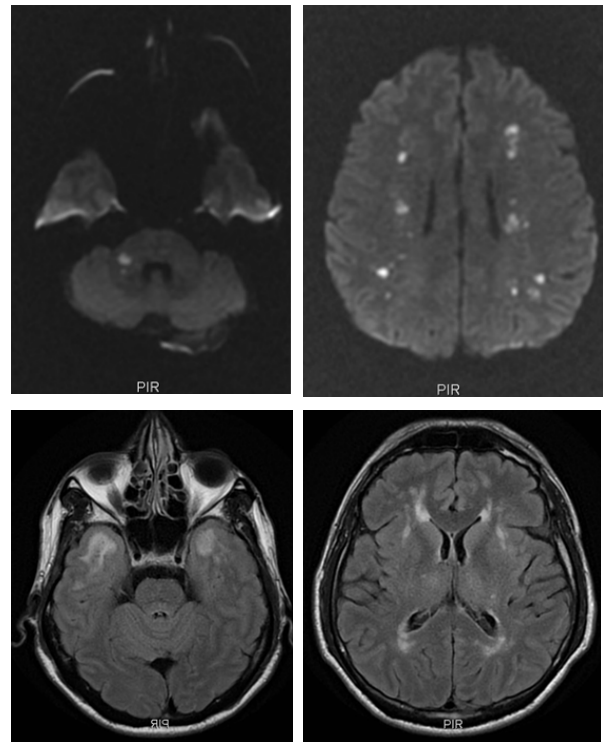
Upper left to right: DWI MRI sequence showing acute infarct in the right cerebellar peduncle; DWI MRI sequence showing multiple subcortical border zone lesions. Lower left to right: FLuid-Attenuated Inversion Recovery (FLAIR) MRI sequence showing white matter chronic periventricular and external capsule lesion; FLAIR MRI sequence showing chronic white matter lesions in the pole of the temporal lobes.
